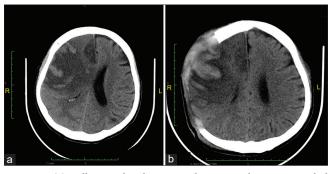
(a) Follow-up head computed tomography scan revealed malignant brain edema with significant midline shift on the right hemisphere and (b) the midline shift reduced after decompressive craniectomy.
